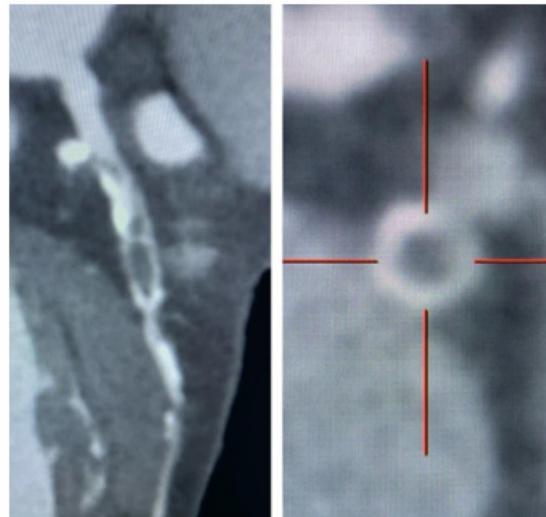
Curved multiplanar reformation and axial CT coronary angiogram image showing 'napkin ring sign' of a high-risk plaque in coronary artery which is prone for rupture.
